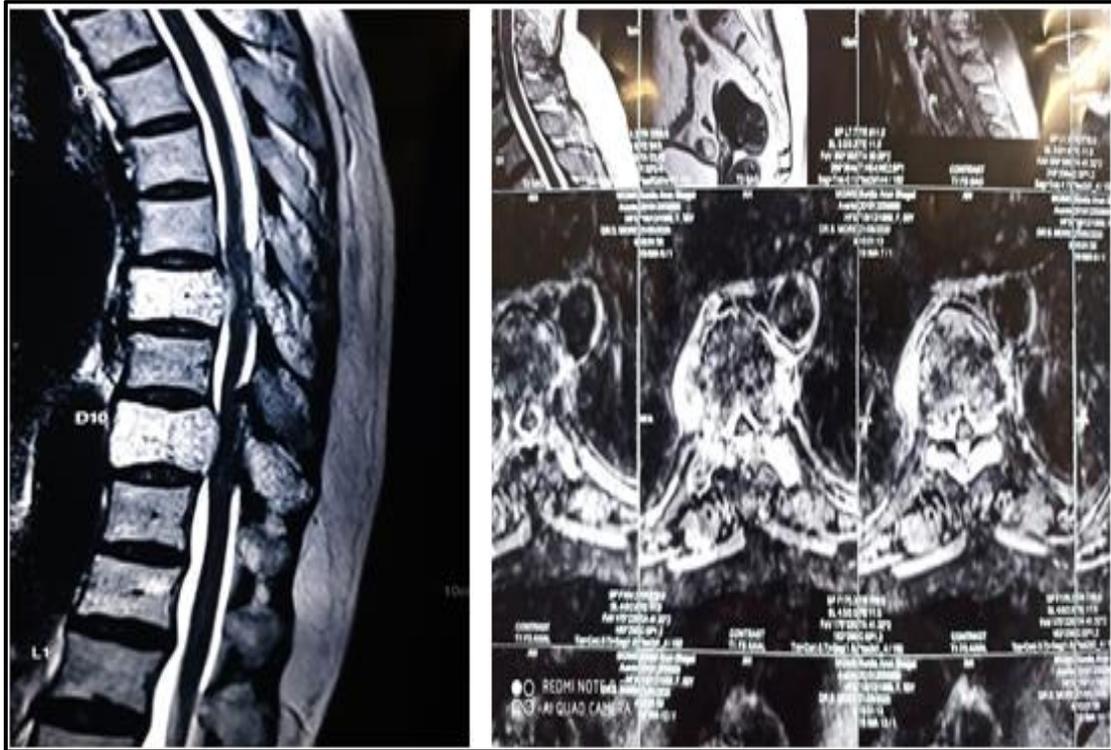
Sagittal and Transverse MRI depicting vertebral hemangioma at D8 and D10 level, involving the anterior, middle, and posterior columns.
